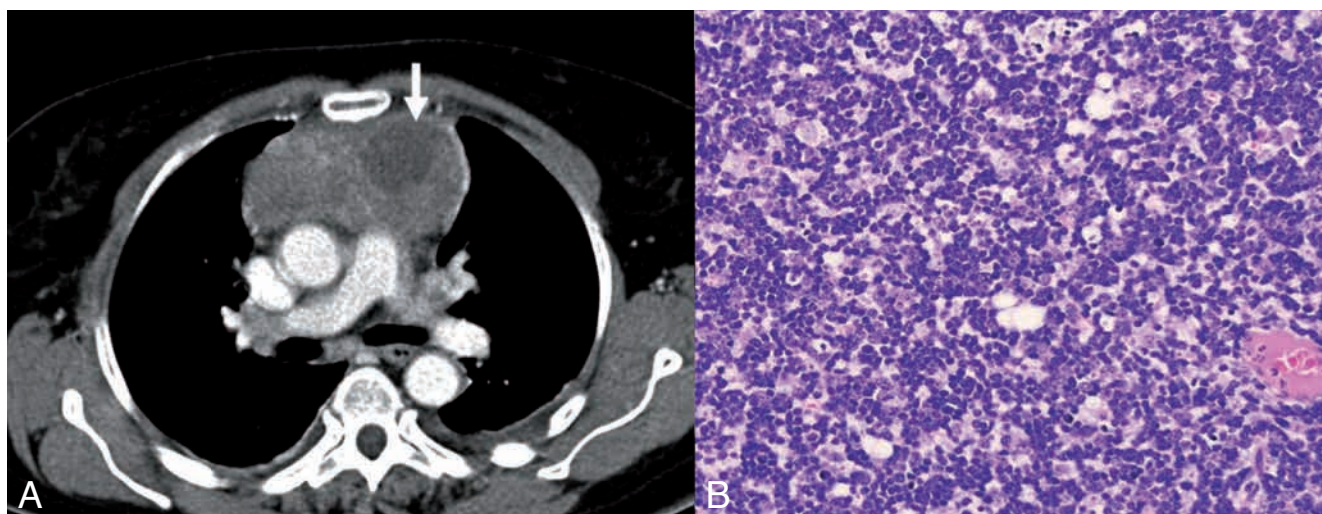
A. Stage I thymoma. A 70-year-old woman complaining of prolonged chest pain was seen in the emergency room. CT shows a sharply defined soft tissue mass with fatty components of 10.2 cm × 4.5 cm × 4.9 cm in the upper anterior mediastinum. At the left side there is a more cystic / necrotic zone (arrow). This mass caused a partial compression of the vena innominata (not shown on this image). Neurologically there were no arguments to withhold the diagnosis of Myasthenia Gravis.
